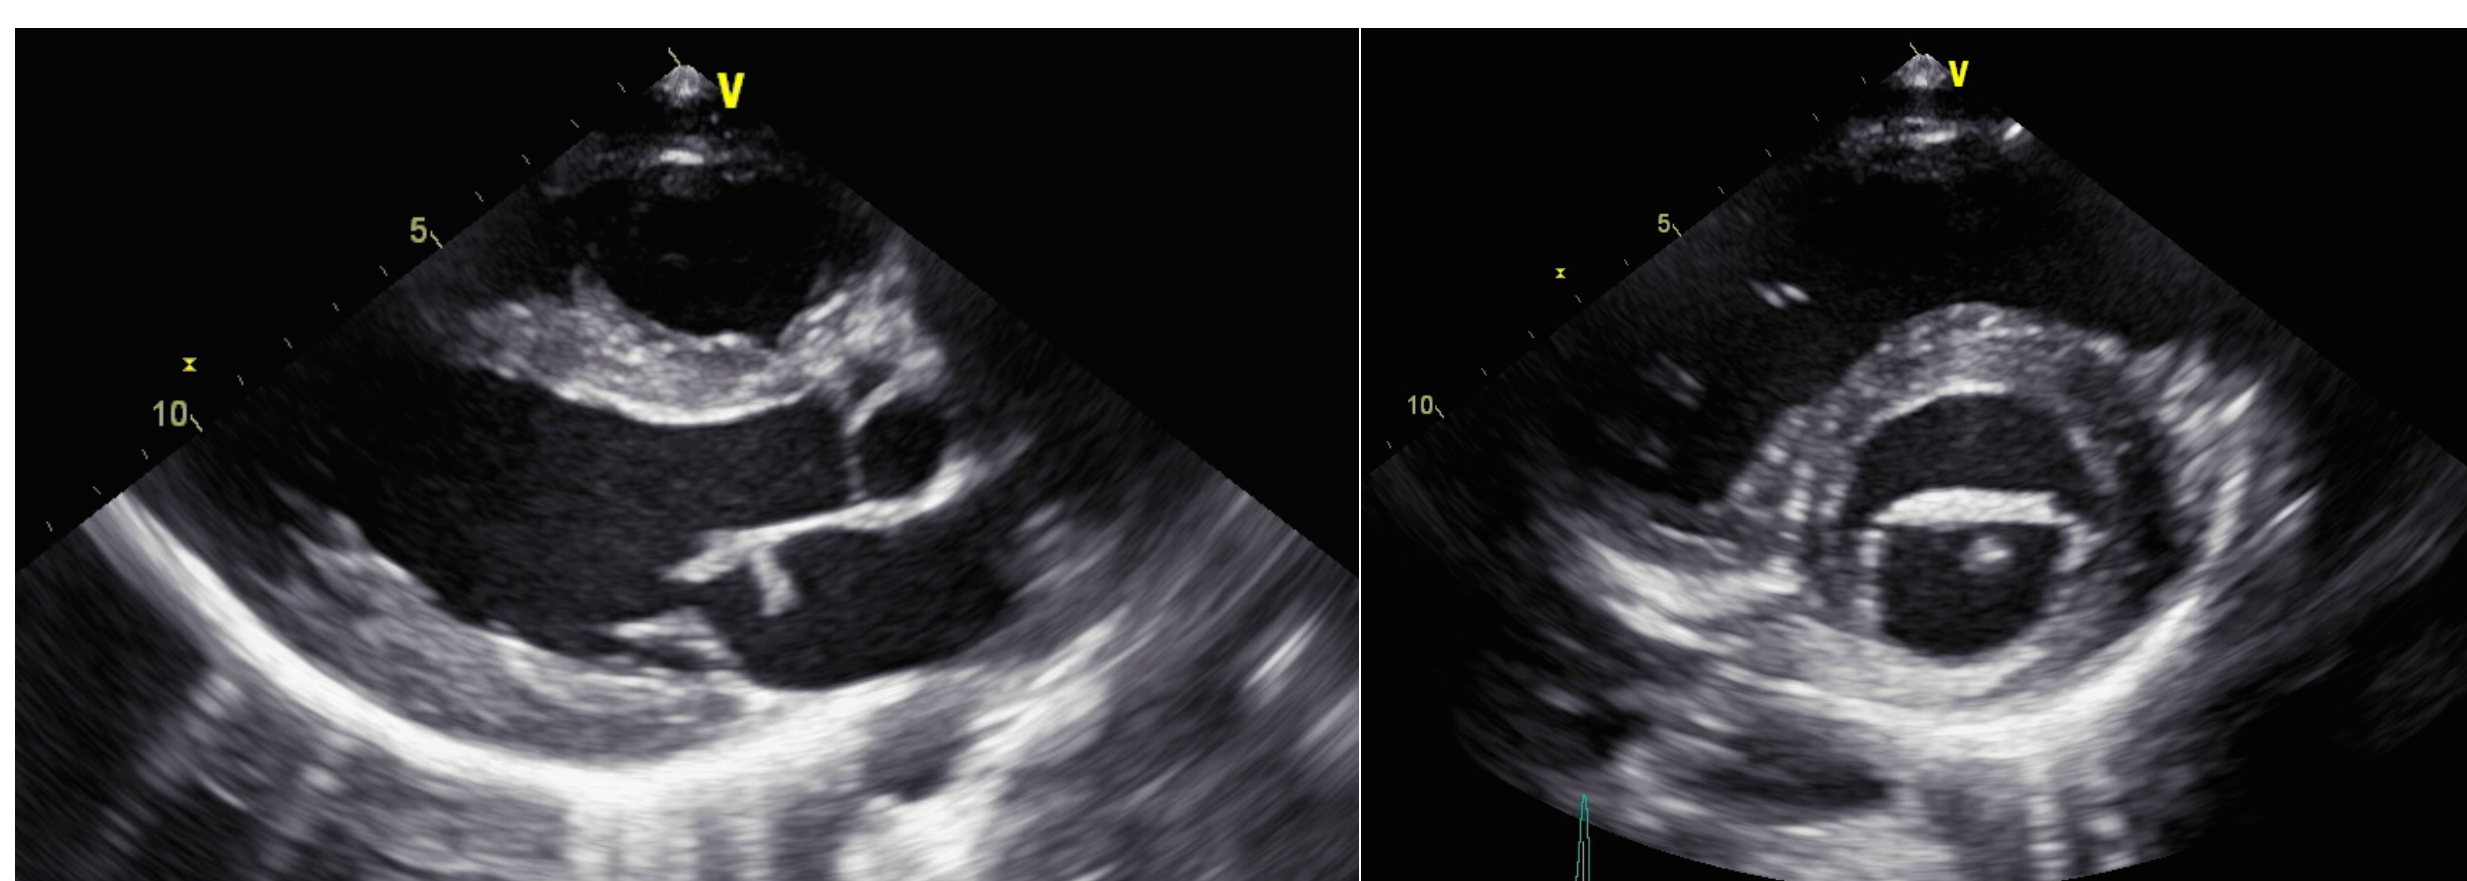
Transthoracic echocardiogram: 1.2 cm mobile structure on the anterior leaflet of the mitral valve
